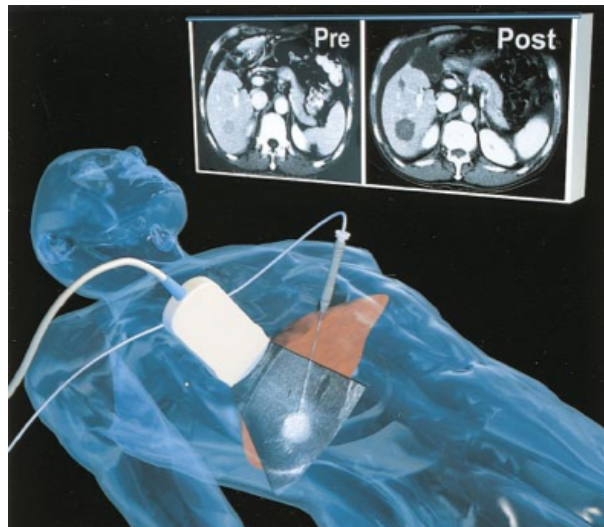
Tumor ablation intervention under Ultrasound-guidance with CT scans of the patient before and after the ablation. Image taken from [1]
